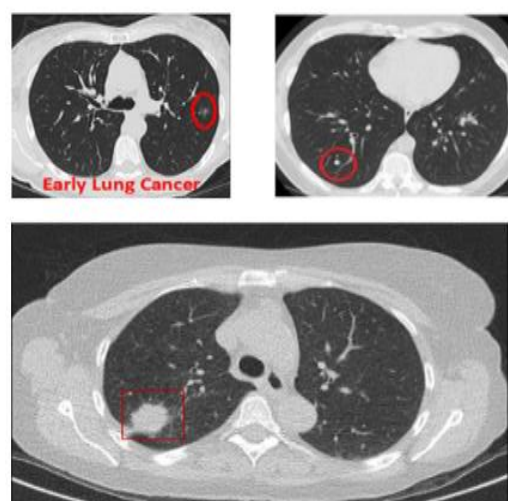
Based on maximum intensity projection CT image. [19]
